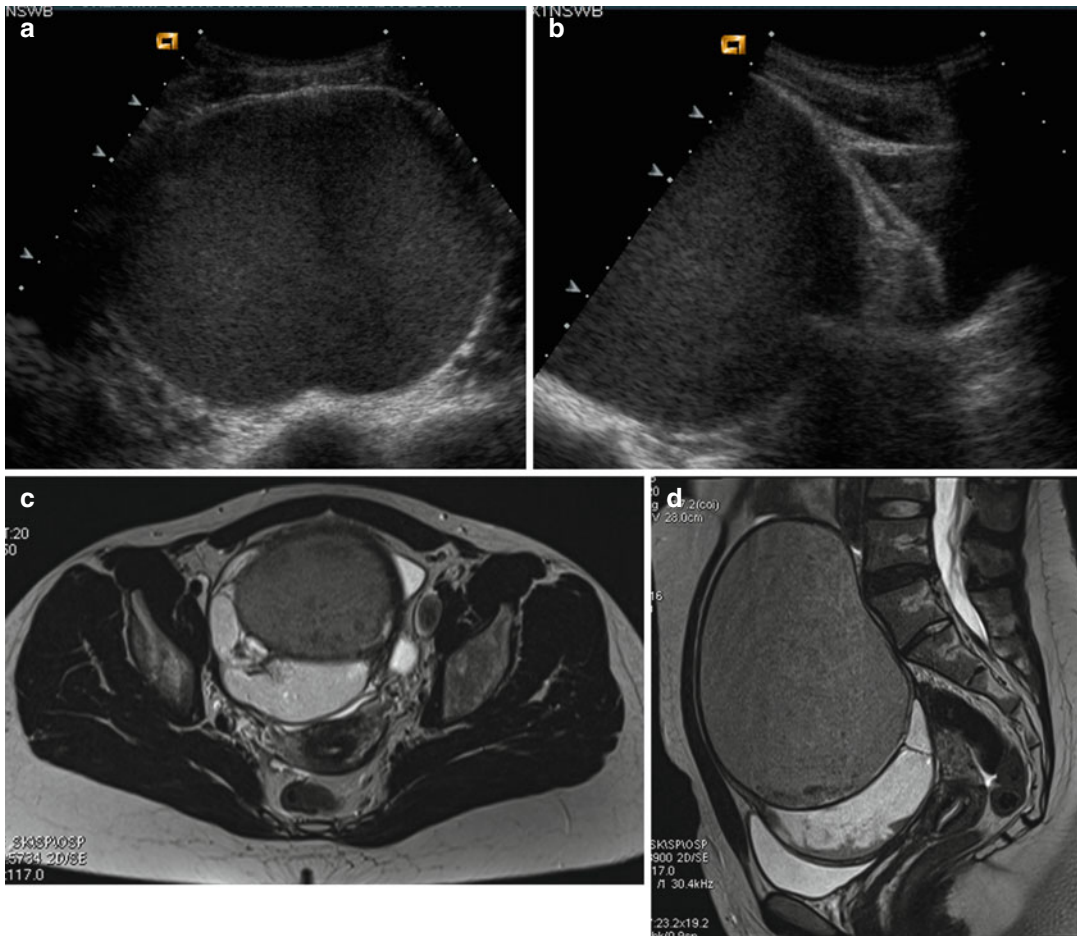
Female, 16 years old. (a, b) Abdominal sonography: (a) axial scan, (b) longitudinal scan: huge fluid corpuscular mass completely filling the pelvic space. Bladder
